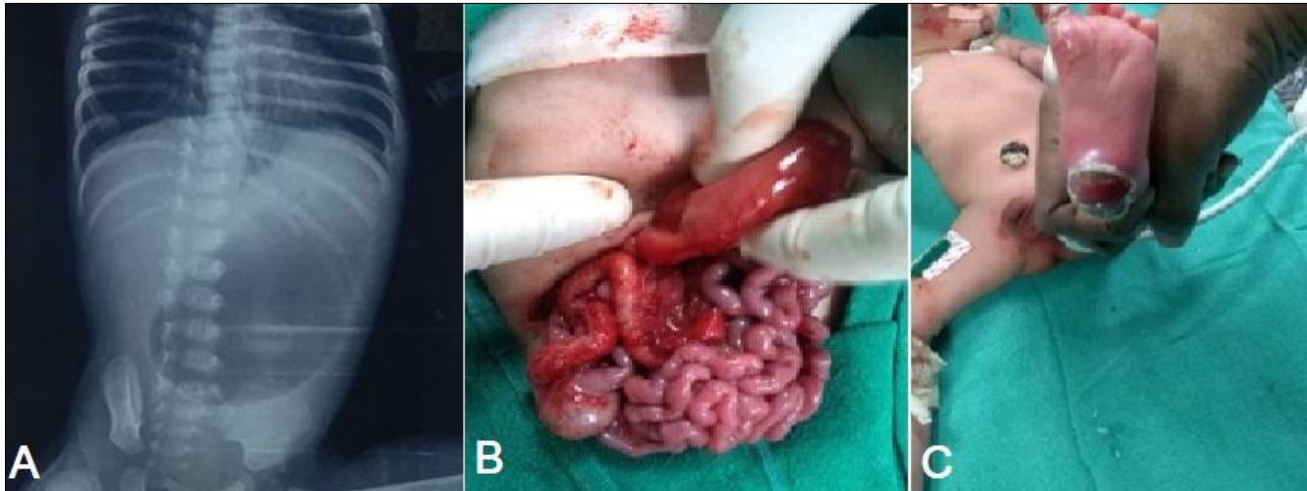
A) Single bubble appearance on X-ray abdomen. B) Intraoperative picture showing CPA. C) Multiple blisters in a case of CPA.
